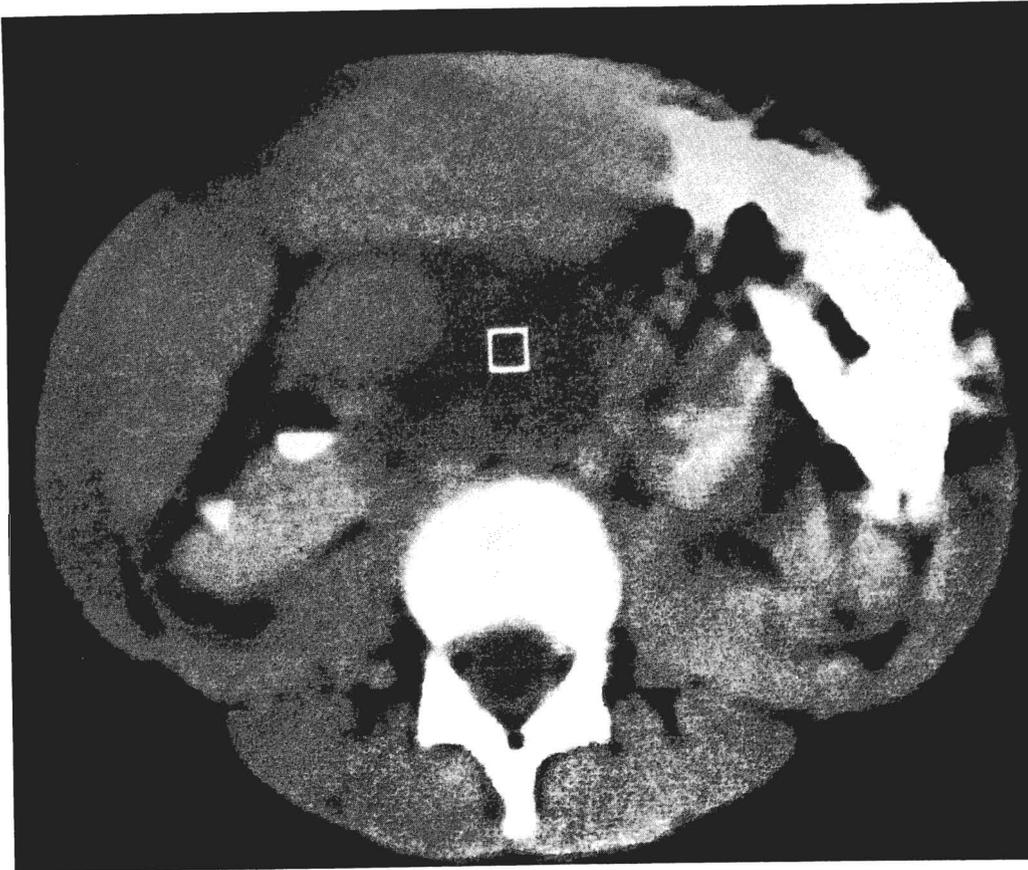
Retroperitoneal hematoma seen by transverse CT scan. (Courtesy of Dr. Alan Daneman)
